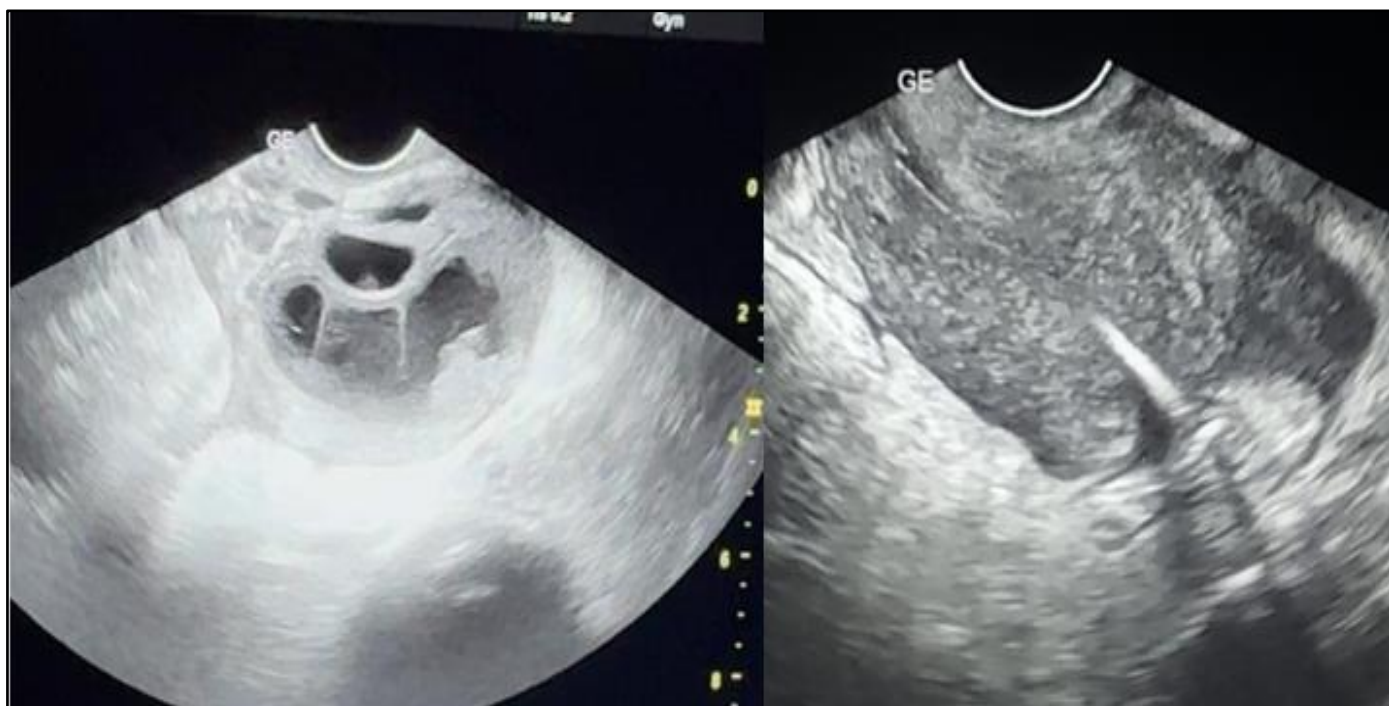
Pelvic Ultrasound Showing a Complex Right Adnexal Mass, Suggestive of a Tubo-Ovarian Abscess. The IUD is not Visualized Within the Uterine Cavity (2).
